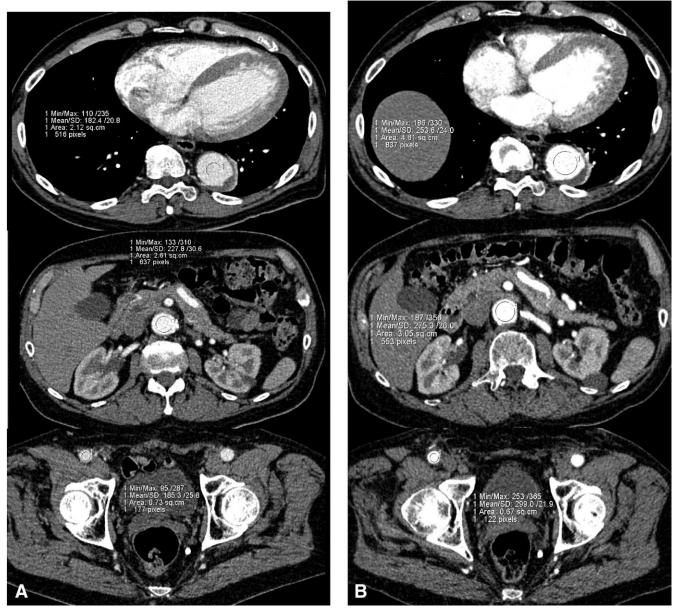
Sixty-two-year-old man with abdominal aortic aneurysm. The patient underwent contrast-enhanced CT for preinterventional evaluation of the abdominal aorta and the aneurysm and for therapeutic planning (A and C). After successful placement of the stent, a control scan was performed (B and D) with saline chasing. Use of the saline chaser bolus enabled us to reduce the total contrast volume from 100 to 80 mL for performing the scan. More importantly, use of the saline chaser bolus resulted in more consistent and higher vascular contrast opacification throughout the entire acquired scan volume, from the most cranial to the most caudal portions (A and C). While there is a marked decrease in contrast attenuation in the proximal abdominal aorta and the iliac arteries in the initial scan without saline chasing (a), there is higher and more uniform contrast enhancement throughout the entire abdominal vascular system when a saline chaser bolus is used (C). This also facilitates threshold-dependent 3D visualization (F) of vascular anatomy and pathology, since a single, predetermined threshold enables uniform rendering of the entire vascular system with saline chasing technique (F), while the proximal abdominal aorta and the iliac arteries "fade out" in different hues in the initial scan (E) due to differing contrast attenuation. In addition, the higher contrast enhancement of the control scan with use of saline chasing enables improved visualization of small mesenteric vessels (F) as compared with nonsaline scanning (E). (Color version of figure is available online.)
